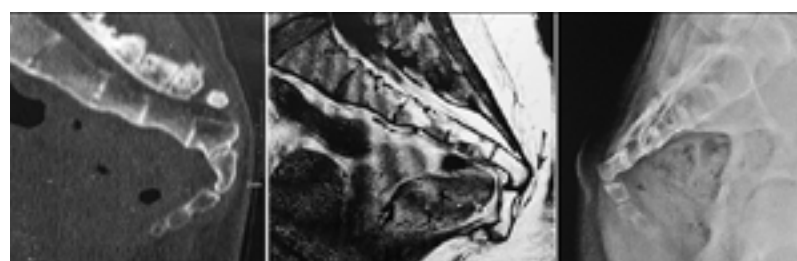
CT, MRI, and x-ray images of the three other cases, showing the concave appearance behind the sacrum and protrusion of the sacrococcygeal angle.
